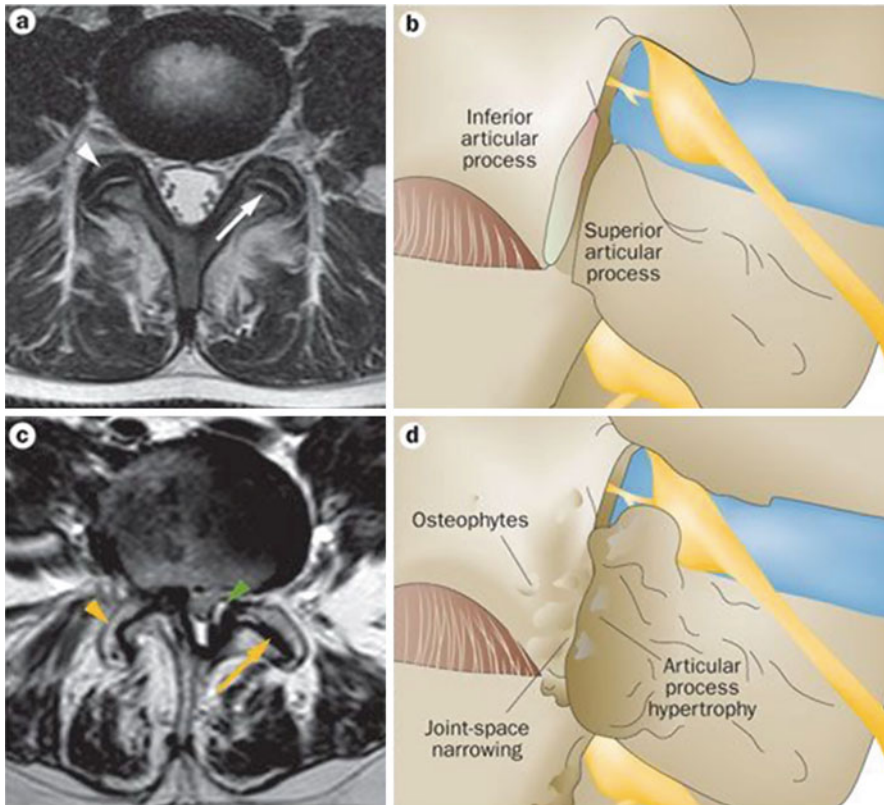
Normal facet joints and advanced facet joint osteoarthritis. (a) T2-weighted axial MRI image of normal facet joints with no joint-space narrowing (white arrow), and no osteophytes or articular process hypertrophy (white arrowheads). (b) Normal facet joints. (c) T2-weighted axial MRI image of osteoarthritic facet joints with joint-space
